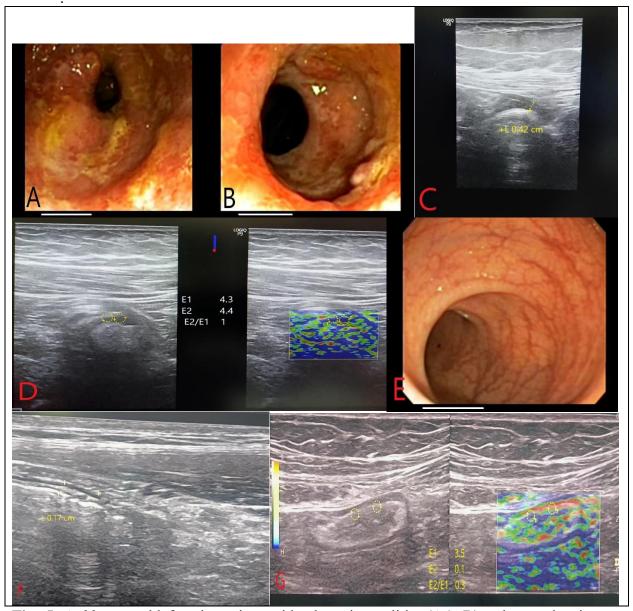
A 33 year old female patient with ulcerative colitis, (A& B) colonscopic picture of rectosigmoid showing easily bleed hyperemic mucosa with exudation, ulcers, small crypt abscesses formation and pseudopolyp, Mayo score 3, (C) ultrasound appearance of rectosigmoid wall showing thickened wall about 0.42 cm with loss of wall layer stratification, (D) shear wave elastography of the rectal wall measuring elastography wave E1 & E2 & SR, (E) colonscopic picture of the rectosigmoid of the same patient after getting in remission showing normal mucosa, Mayo score 0, (F) ultrasound appearance of the rectosigmoid wall showing normal wall
